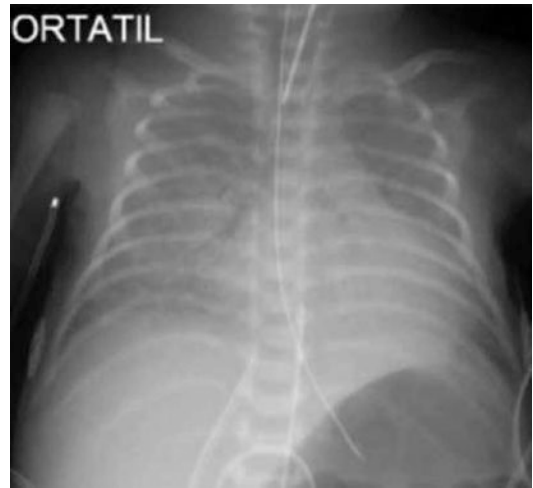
Persistent arterial duct. Chest X-ray of a 31 weeks newborn who, at 10 days of life, presents with respiratory worsening related to a hemodynamically important ductus
